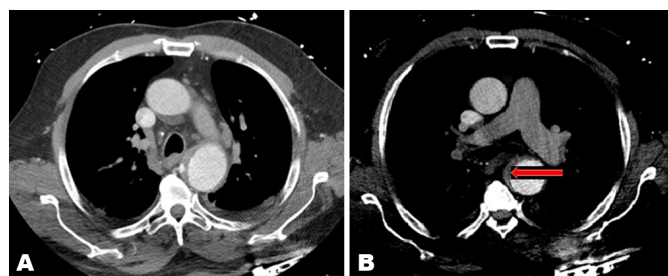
(A, B): Computed tomography scan images 24 hours after the second focus of contrast material within the intramural hematoma just below the level of the carina was no longer present.
